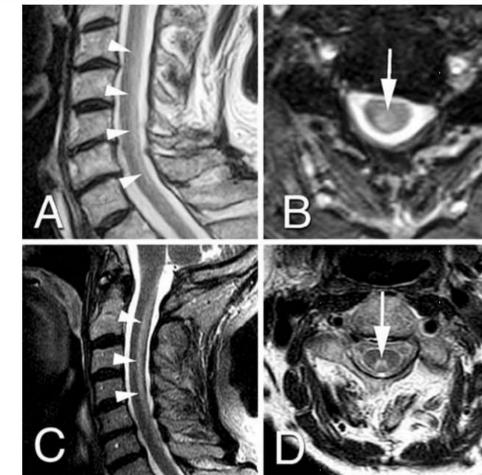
Sagittal and axial T2-weighted images of the cervical spine in two patients (A,B and C,D) showing increased T2 signal involving the midline dorsal cervical cord. T2 hyperintensity involved both the central and dorsal cord in B, while only the dorsal columns were involved in D. Our patient presented with normal MRI findings (Reproduced from PMID: 16261334).
